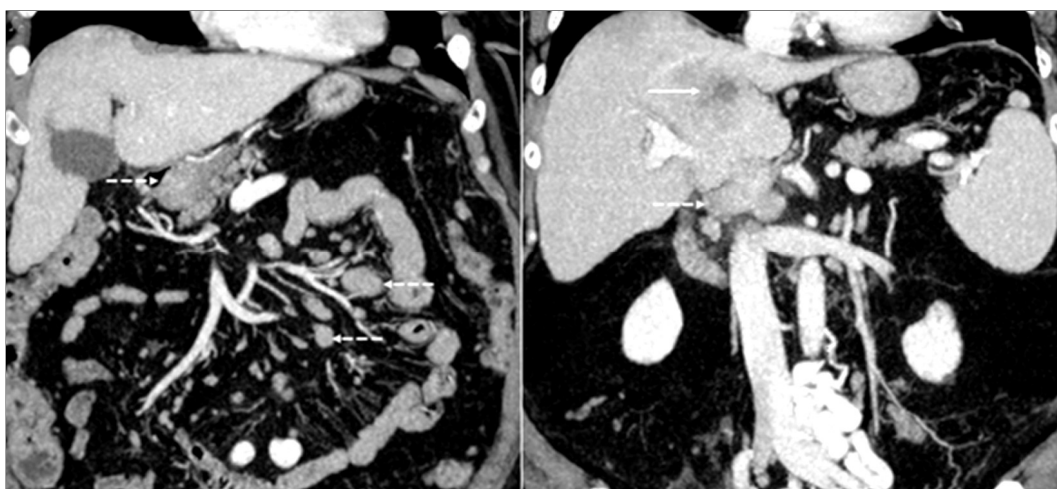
Thoraco-abdominal CT scans – showing liver nodules (white arrow), multiple abdominal adenopathies (dotted arrows) and costal lesions.
